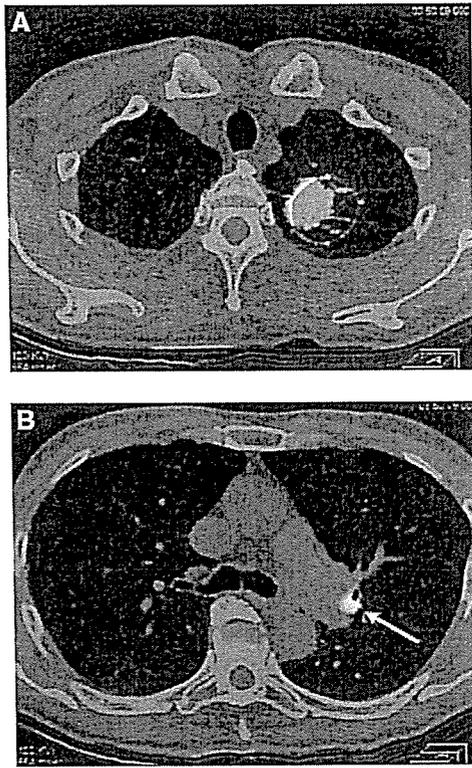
Fused SPECT/CT images in lung cancer of the left upper lobe. A, Primary tumor. B, Radiolabeled lymph node (segmental nodal station) can be detected (arrow).
